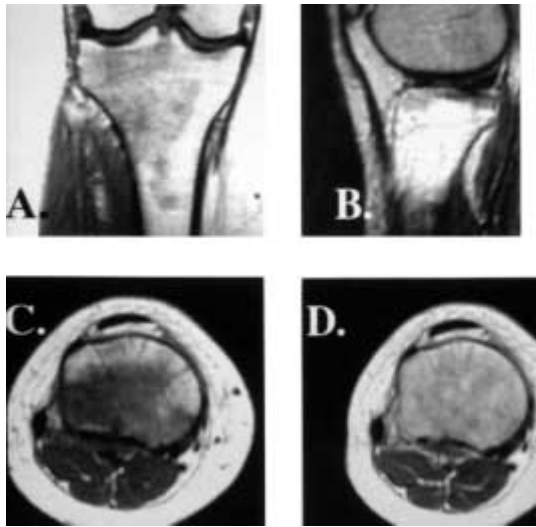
An MRI scan of the same case as fig. 3. a : T₁-weighted AP-image demonstrates an area of low signal intensity within the proximal tibial cancellous bone. b : T₂-weighted lateral image demonstrates high signal intensity supporting the presence of bone marrow edema. c : Axial T₁-weighted scan shows an area of low signal intensity. d : following gadolinium enhanced signal is noted.
